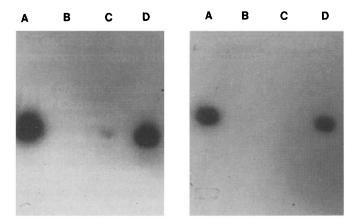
Southern blot analyses of PCR products. Portions of the PCR reactions (20 µl) were electrophoresed in a 2% agarose gel, blotted onto Duralose, and then probed as outlined in Materials and Methods. The samples were separated from each other by two empty lanes to avoid cross-contamination. The X-ray films were exposed for 1–2 h at room temperature. Left, pol-specific primers and probe; right, ICP6-specific primers and probe. A, purified HSV-1 DNA; B, mock-infected ganglia DNA; C, ICP64-infected ganglia DNA; D, KOS-infected ganglia DNA.
